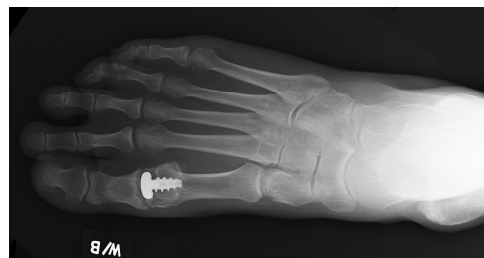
5 year follow-up radiograph after metatarsal head resurfacing (HemiCAP® Toe I)
